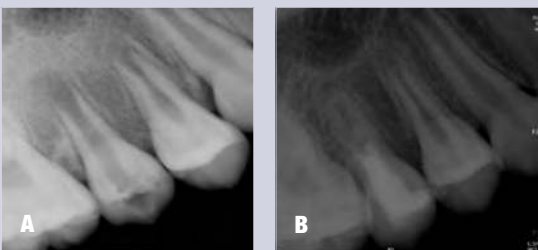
(A) Preoperative radiograph of tooth #4. (B) 5-year follow-up after regenerative endodontic treatment. Reprinted with permission from Jung IY, Lee SJ, Hargreaves KM. Biologically based treatment of immature permanent teeth with pulpal necrosis: a case series. J Endod 2008;34:876-87.
